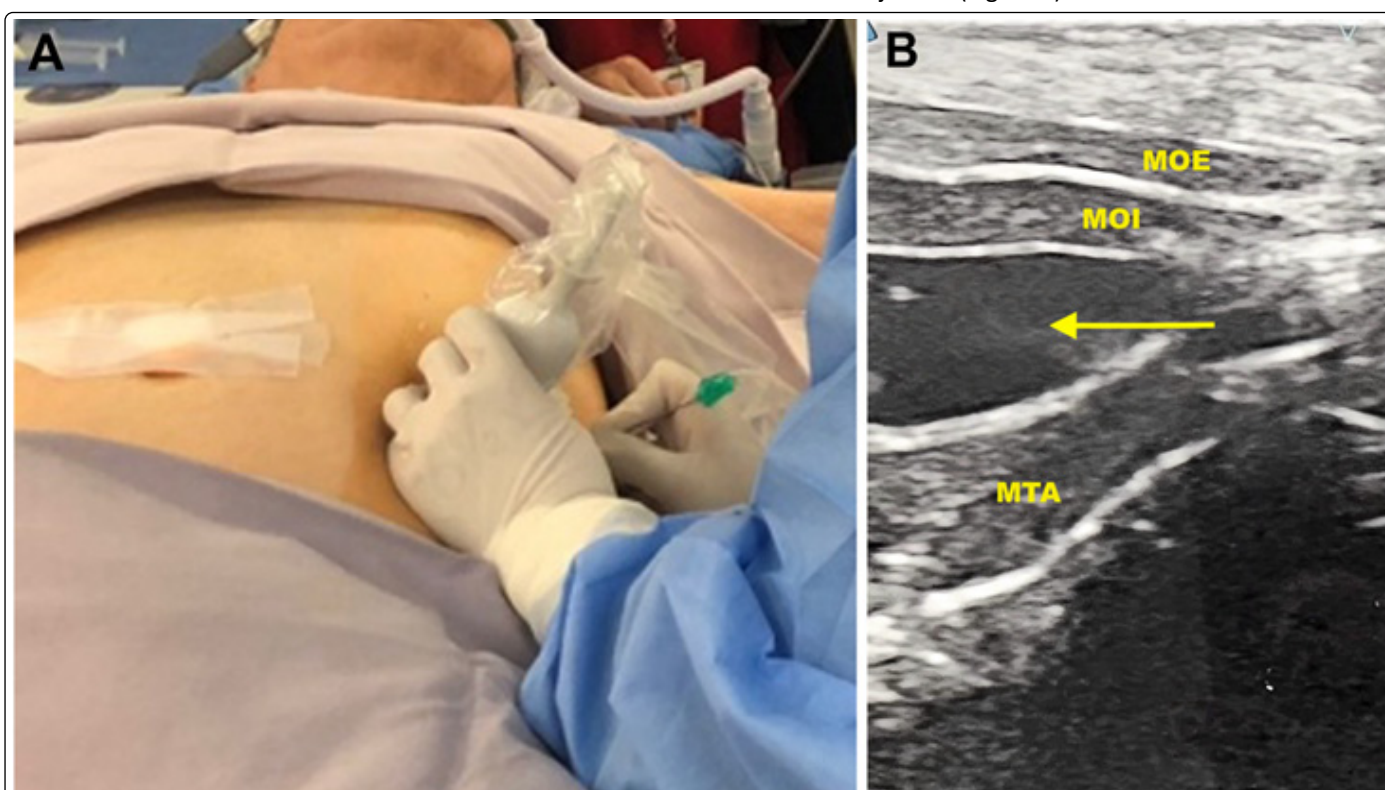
TAP block placement technique. (A): Patient in supine decubitus position, ultrasound transducer perpendicularly to anterior axillary line, between iliac crest and costal margin, and needle insertion in the plane; (B): Identification of MOE, MOI, MTA, and peritoneum via posterior approach; Hydro dissection and local anesthetic infiltration are noted (Yellow arrow).
